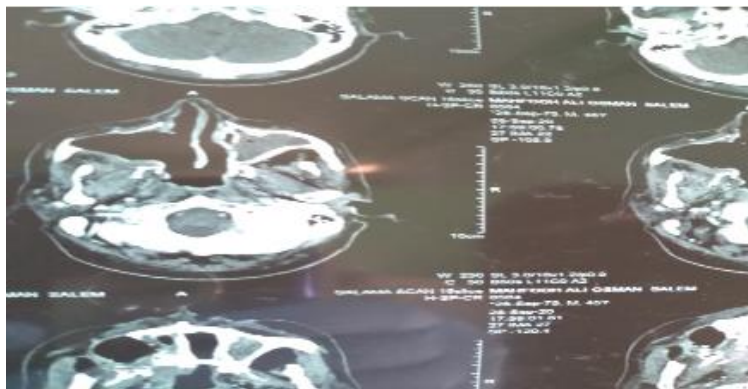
CT scan: axial cut of upper neck with IV contrast showing destructive mass*
